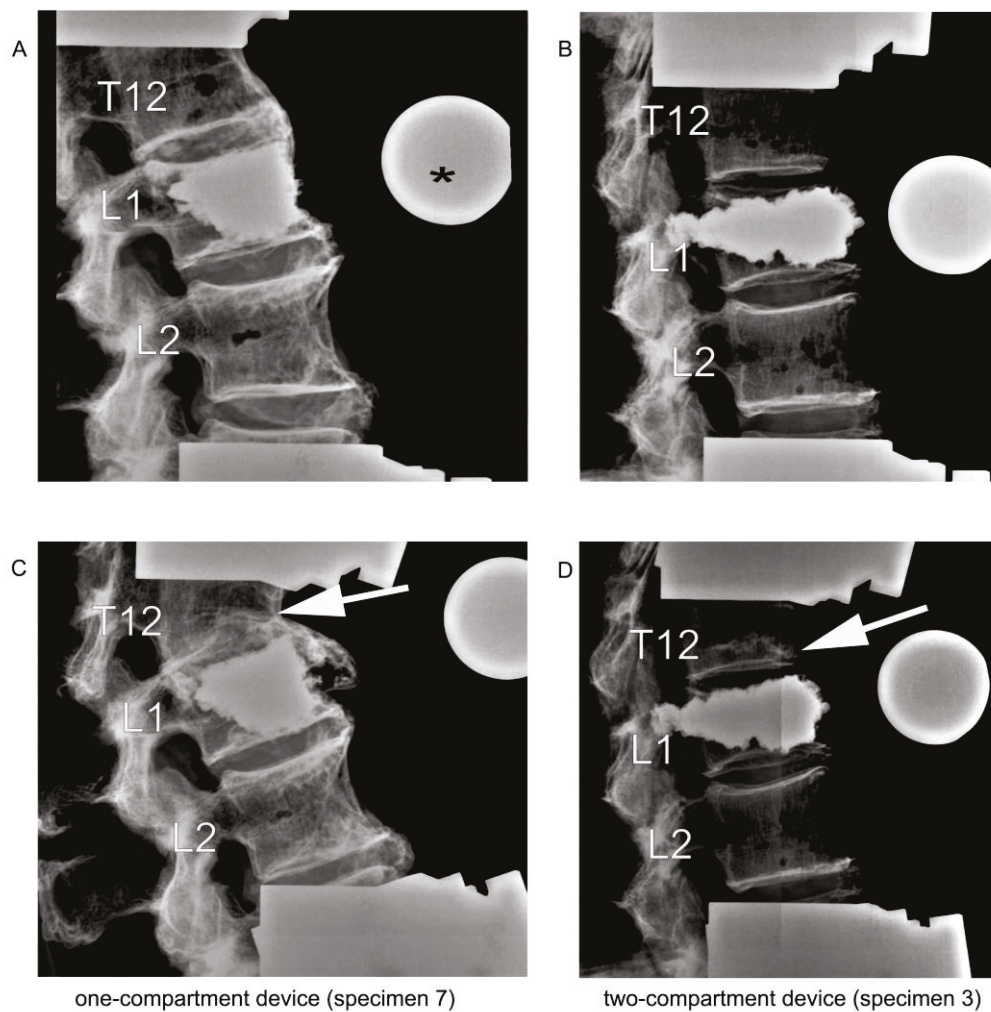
Lateral radiographic images upon kyphoplasty of L1 (A,B) and after adjacent fracture of T12 (C,D) resulting from the cyclic loading test of load-bearing capacity. The asterisk (*) in (A) refers to the radiographic reference ball. The arrows in (C,D) point to the fractured T12.
